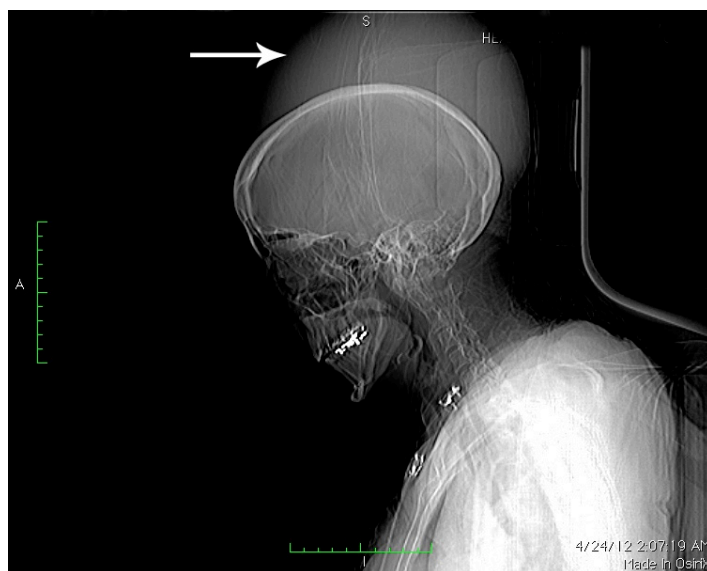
Computed tomography scout film demonstrating cephalohematoma.
